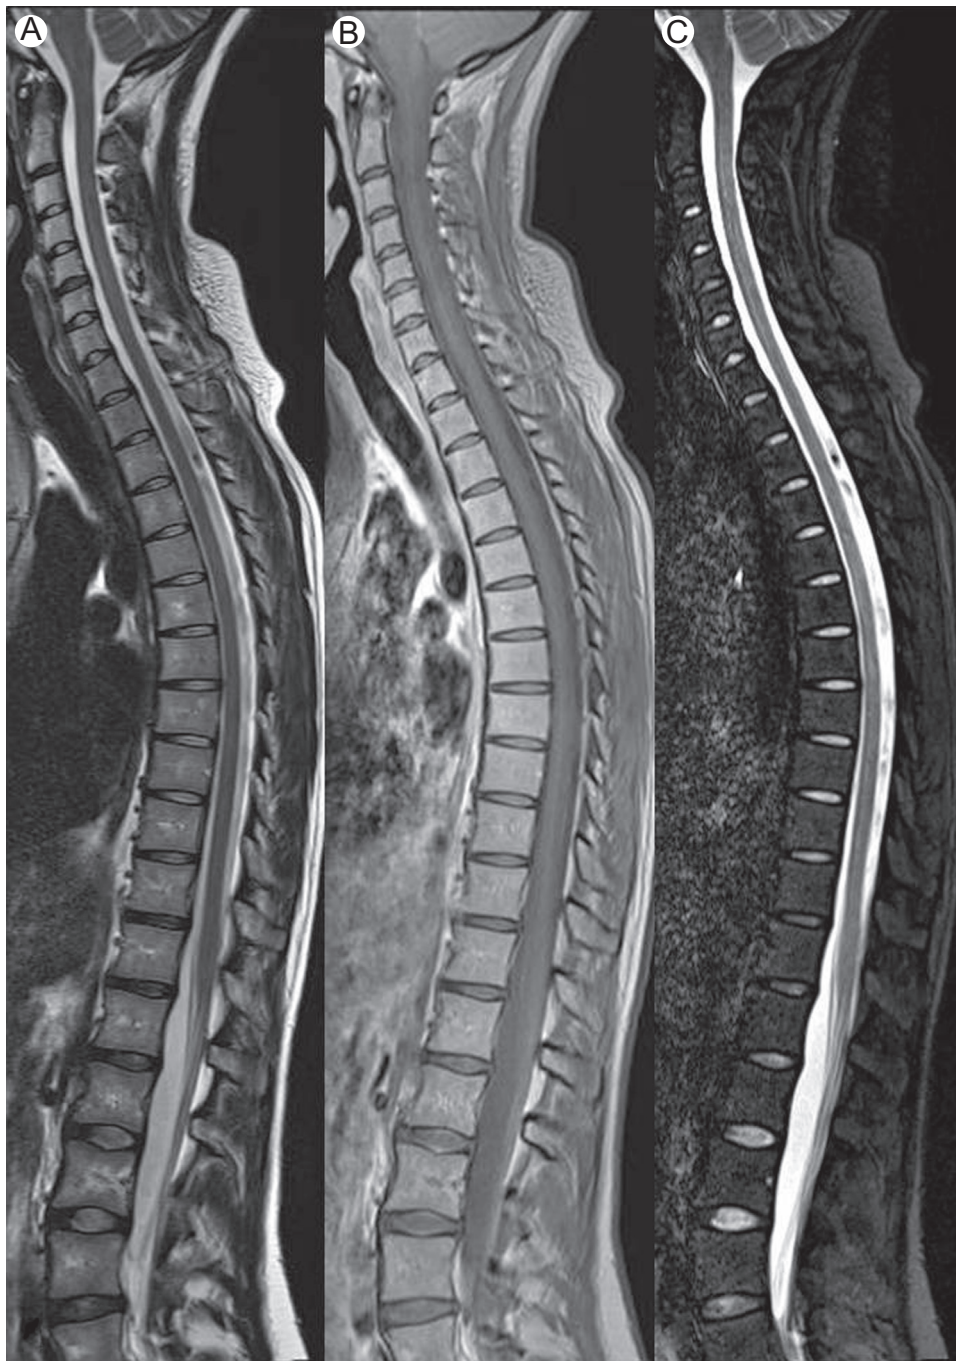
Whole spinal cord MRI in a normal individual. The combination of phased-array coils and fast imaging sequences allows complete coverage of the spinal cord in acceptable acquisition times. (A) T2-weighted sequence, (B) proton density-weighted sequence, and (C) short-tau inversion recovery (STIR) sequence.
